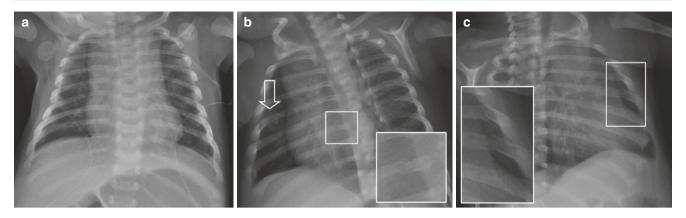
Infant with multiple bruises. (a) Chest radiograph shows multiple healing lateral and fresh posterior rib fractures. (b) Repeat chest radiograph shows multiple healing rib fractures in nearly all ribs
